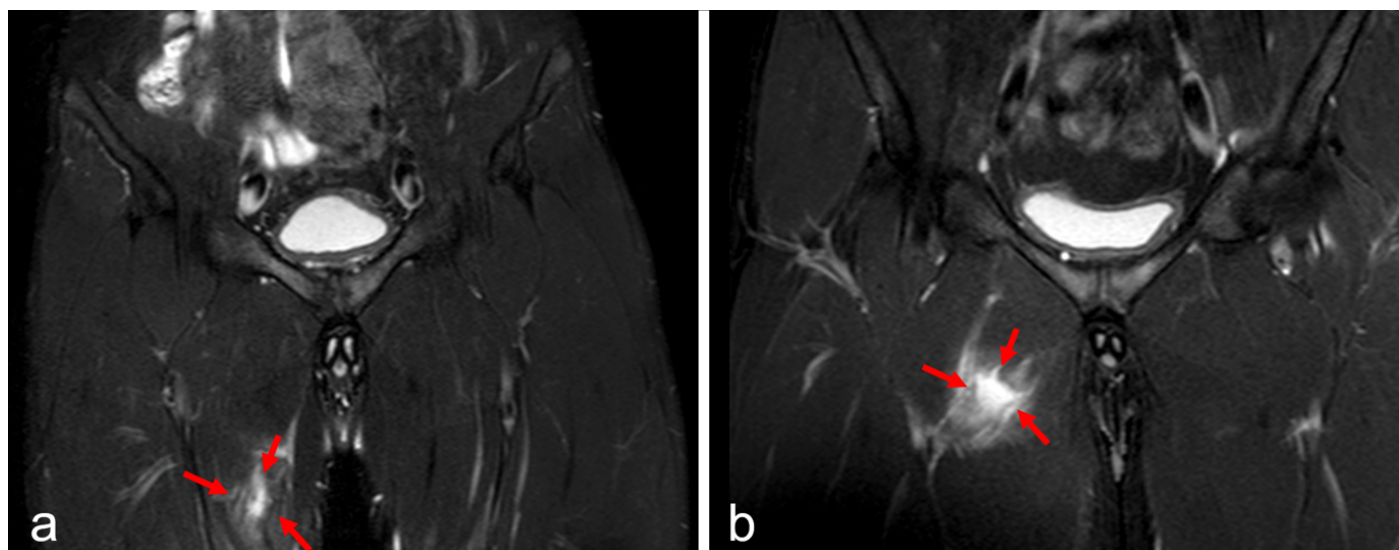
Coronal T2-weighted MR images of two different football players with Type 1 adductor lesions (strain injuries). (a) Hyperintense signal changes are observed within the adductor longus muscle belly and musculotendinous junction, consistent with edema and partial fiber disruption. (b) A more extensive hyperintense area is visible at the proximal myotendinous junction, indicating a more severe strain. Red arrows indicate regions of muscle edema and architectural distortion within the adductor compartment.
